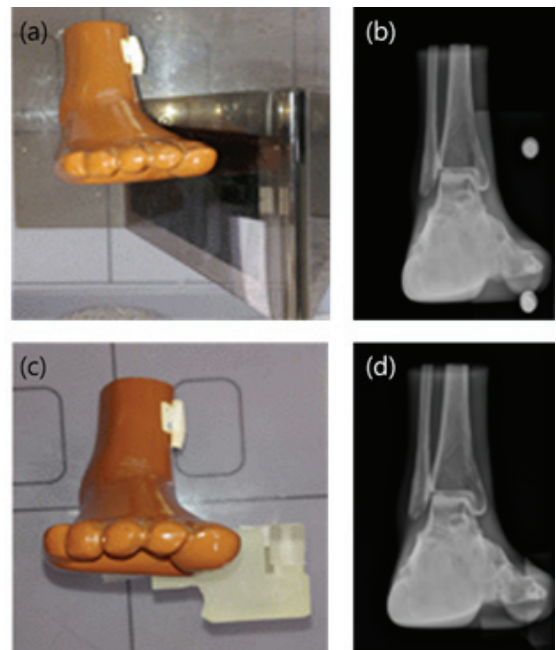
Radiograph image comparison between hologic tool and SHD.
